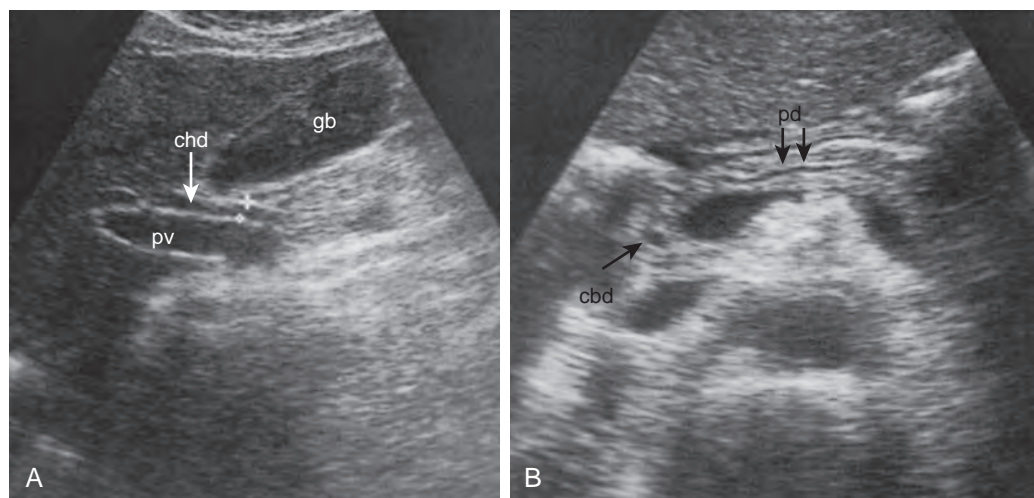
Extrahepatic biliary anatomy: ultrasound. A. Sonographic demonstration of the common hepatic duct (chd, arrow) located anterior to the portal vein (pv). Note the gallbladder (gb) anteriorly. B. Normal distal common bile duct (cbd, arrow) is seen in the head of the pancreas on a semierect transverse sonogram. Pancreatic duct (pd, arrows) is also seen.
